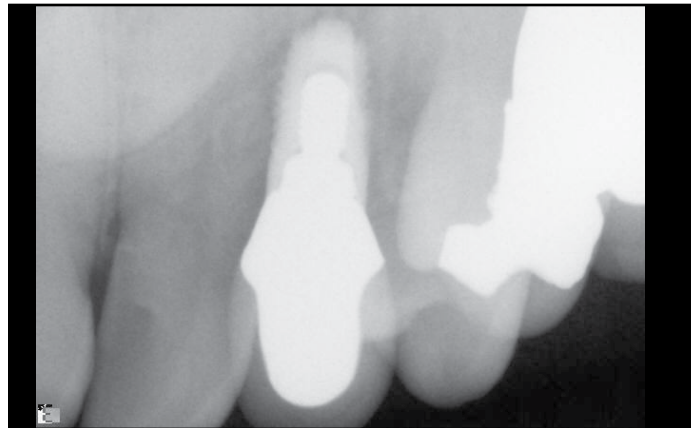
Final radiograph suggests good crown margins and the implant just avoiding the impacted cuspid.
